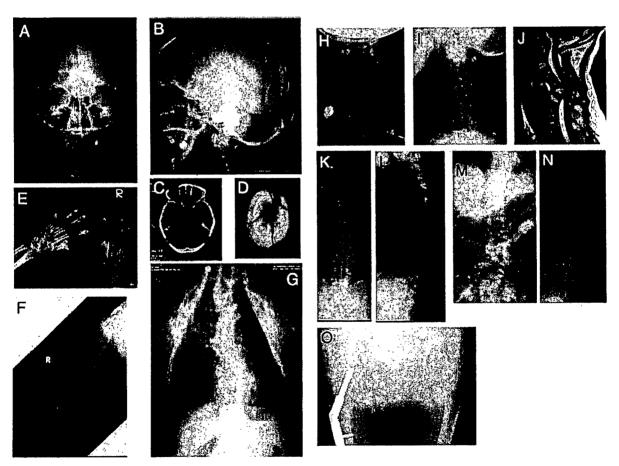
Radiological examinations of the patient at age 56 years, A,B,E-I,K-O: Skeletal radiographs: C,D: CT scans of the skull. J: MRI of the cervical spine.
